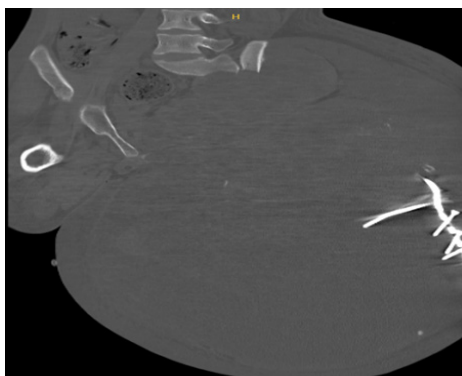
Computed Tomography image at admission
